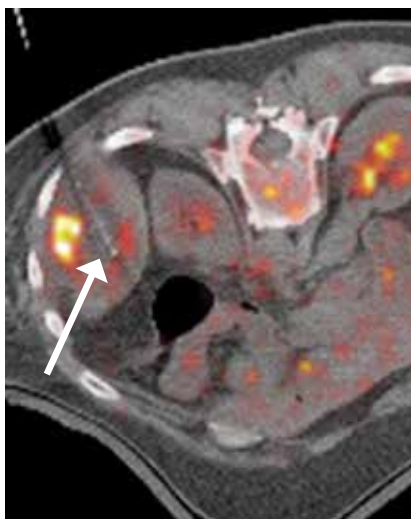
Fused PET/CT demonstrating the superior cryoablation probe (white arrow) placed within the necrotic medial part of the tumor.
